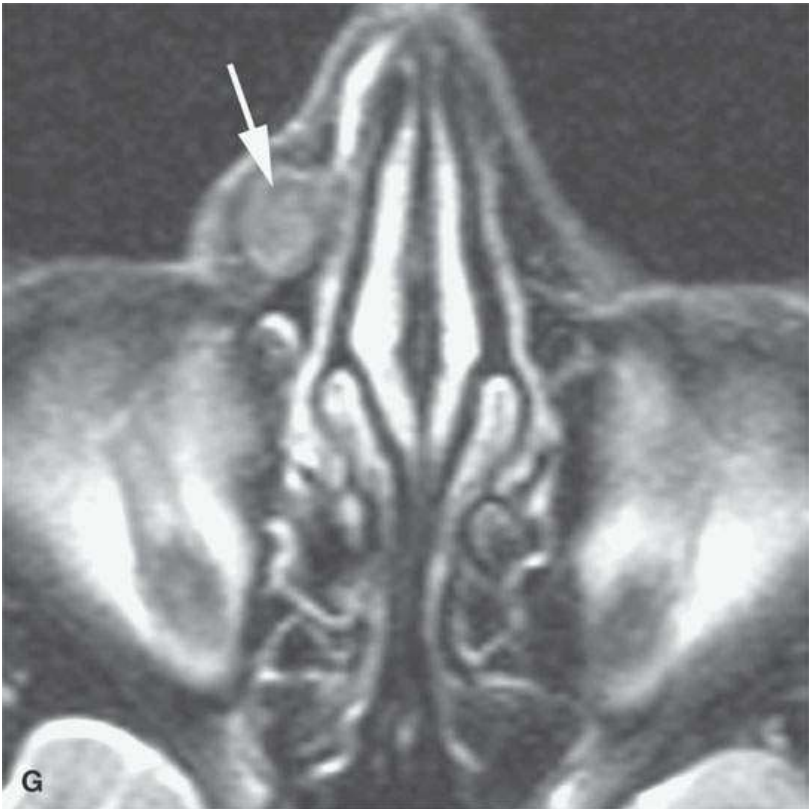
Magnetic resonance imaging (MRI) of a patient with sebaceous cell carcinoma of the nose invading the nasal cartilages (*arrows*) as compared to the opposite normal side (*arrowhead*) seen in (A) through (C). Bone involvement is uncertain but confirmed by computed tomography (*arrow* in D) compared to the normal opposite side (*arrowhead*). E–G: MRI shows continued spread beneath the superficial musculoaponeurotic system (*arrows*) and sparing the subcutaneous fat, ((*arrowheads*) an extension that was difficult to appreciate clinically. H, I: MRI that excludes gross perineural spread along the infraorbital and supraorbital nerves, respectively (*arrows showing normal neurovascular bundles beneath SMAS*).
